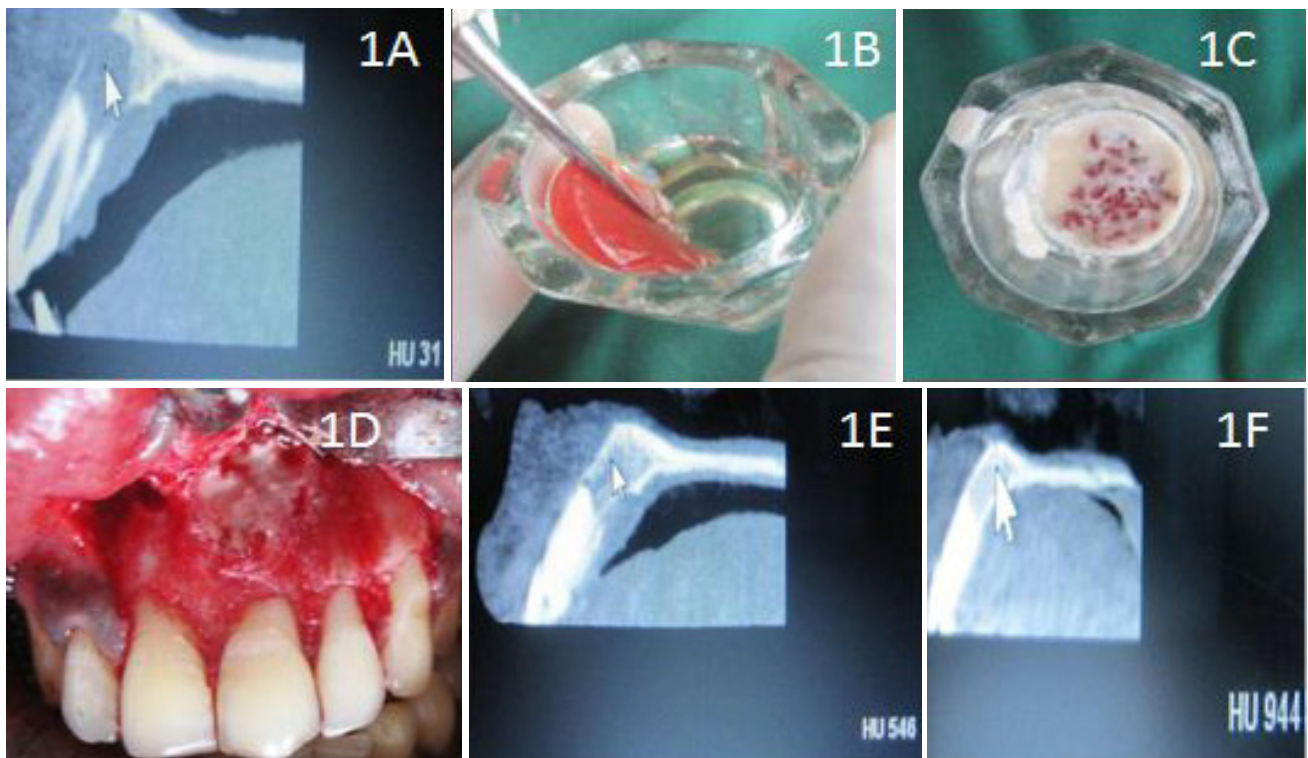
A. Preoperative CBCT image with HU value; B. Preparation of PRP gel; C. Mixing of PRP with β -TCP; D. Placement of PRP + β -TCP in the defect; E. 6 months post-op CBCT image with HU value; F. 1-year post-op CBCT image with HU value.
